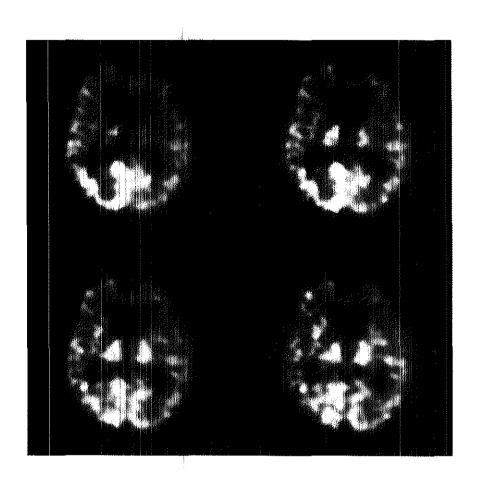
SPECT scans of a patient from family I showing marked frontotemporal hypoperfusion.
